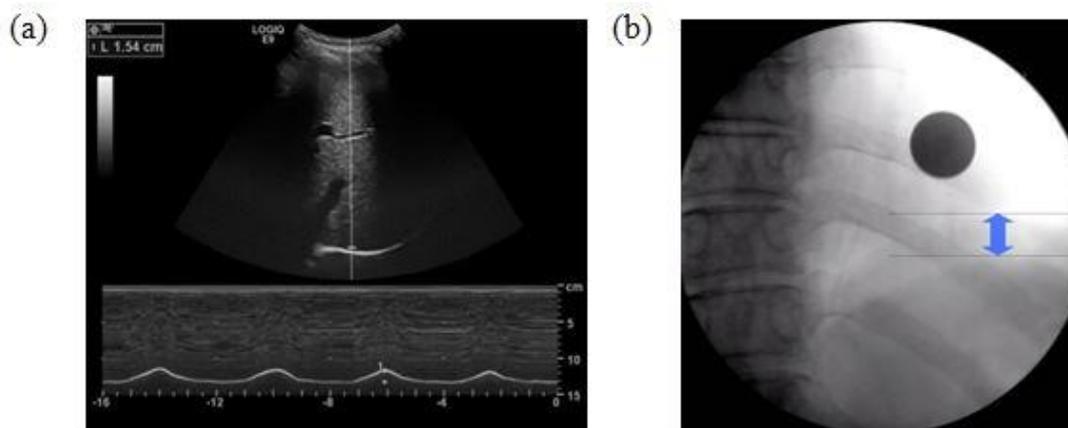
Measurement of diaphragm excursion using (a) ultrasonography and (b) fluoroscopy
